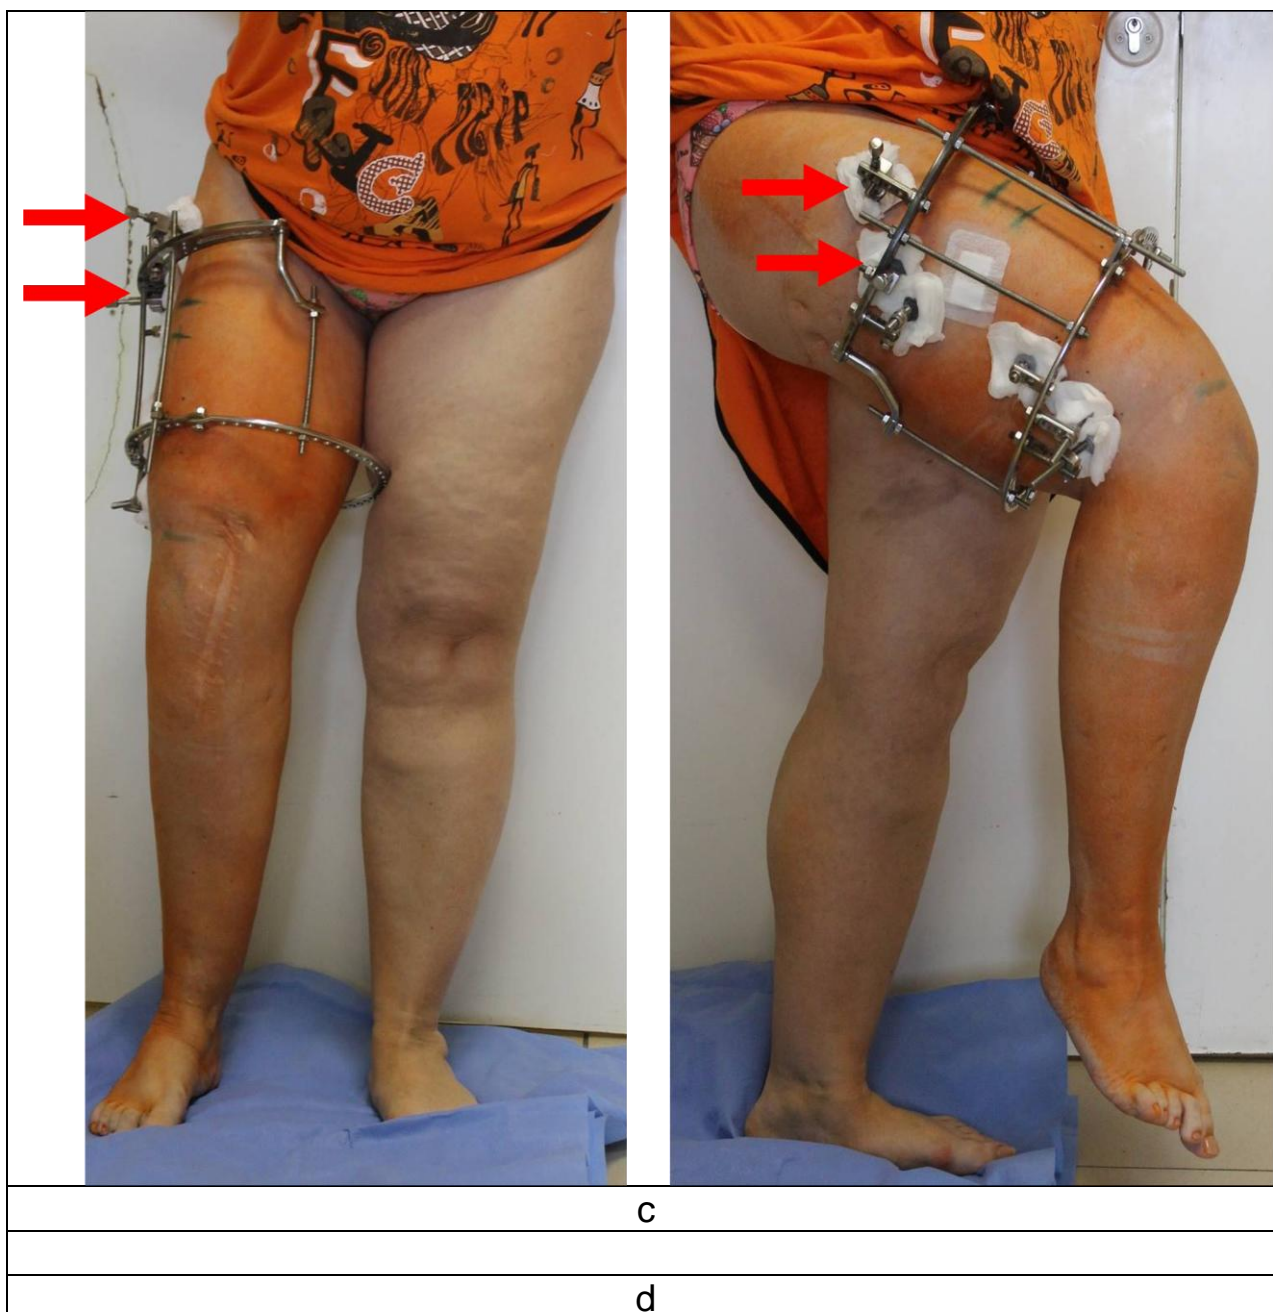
Photos and x-rays of patient L., 70 y.o., with interprosthetic deformity: a – before the surgery; b, c – deformity correction using Ortho-SUV Frame on base of SUV-CLAMPs (SUV-clamps are pointed by arrows); e – result of treatment
